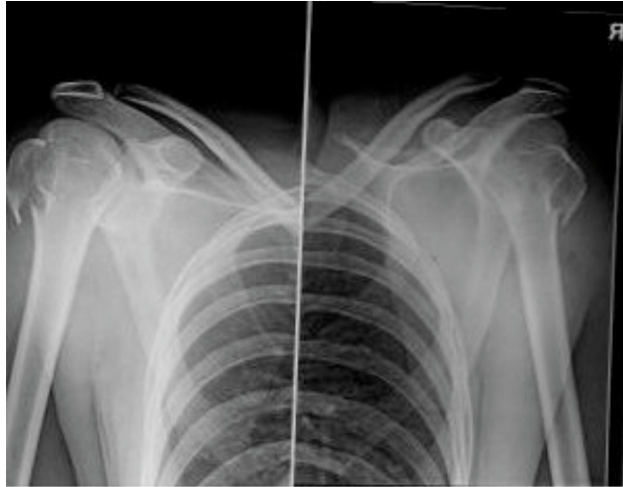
Post Reduction X-Ray.
